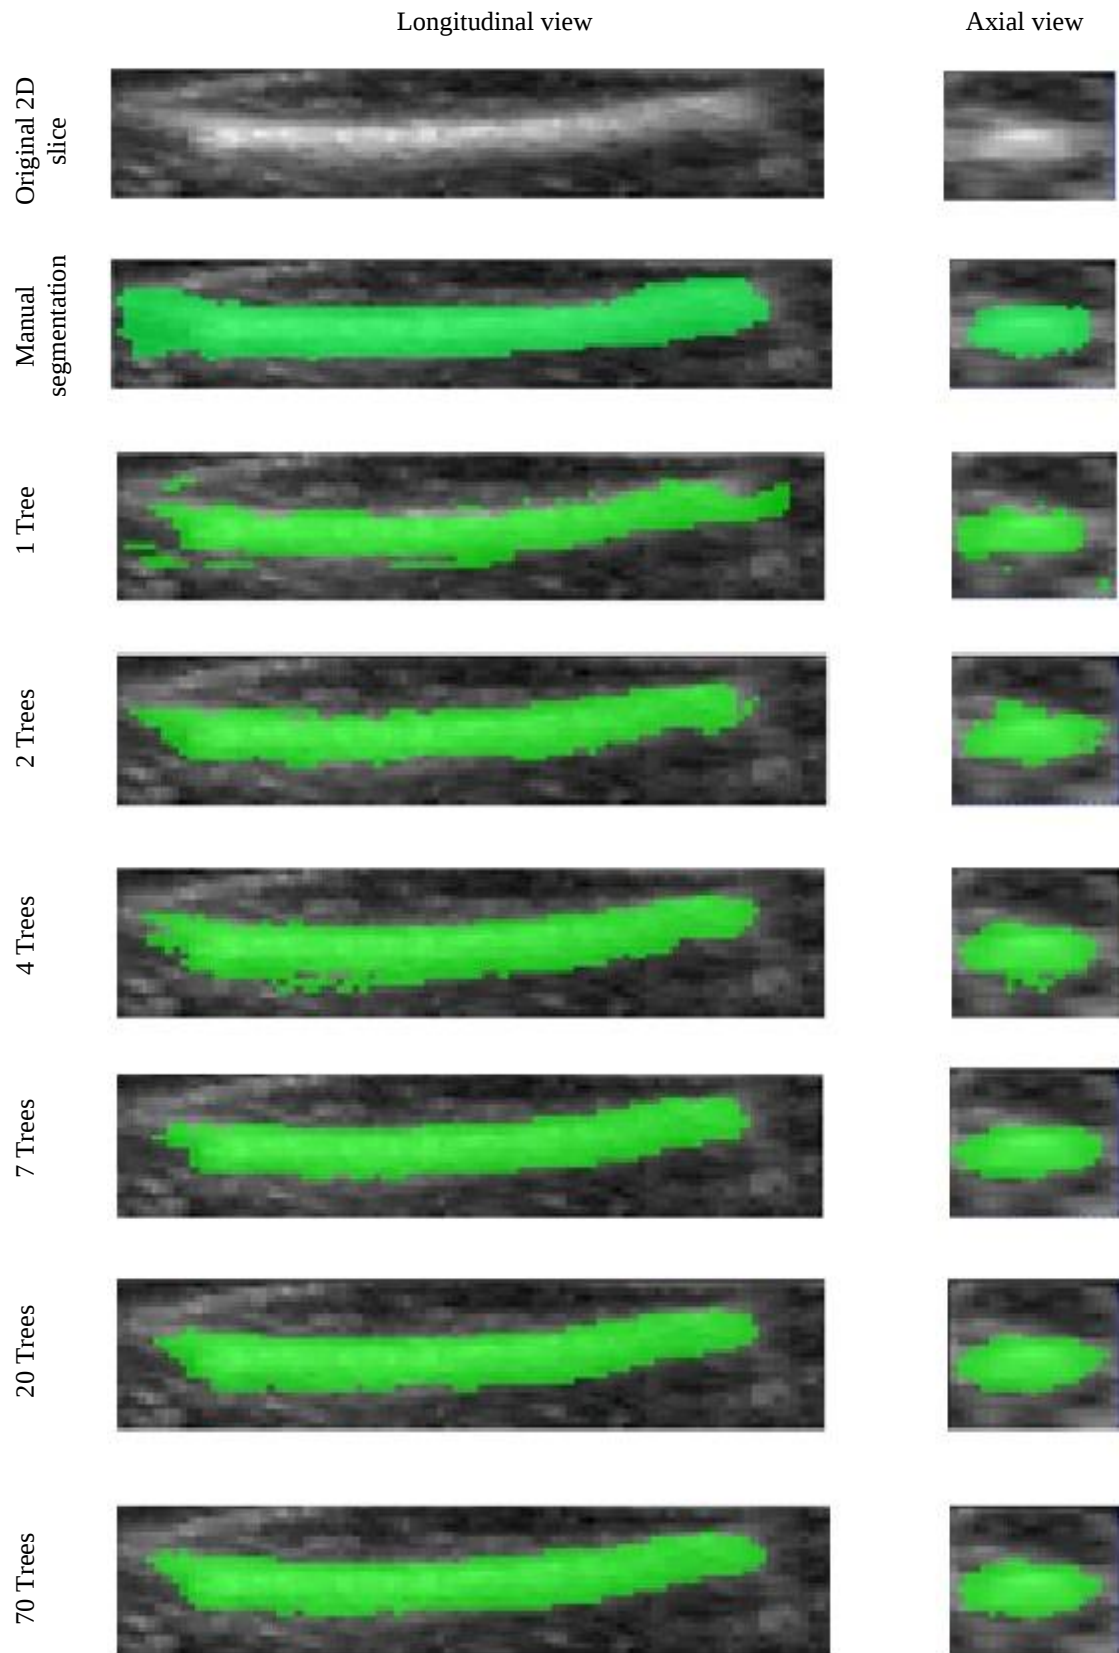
2D slices that show the segmentation of the fetal femur in 3D ultrasound using the classic Random Forests which is trained on different number of trees.
